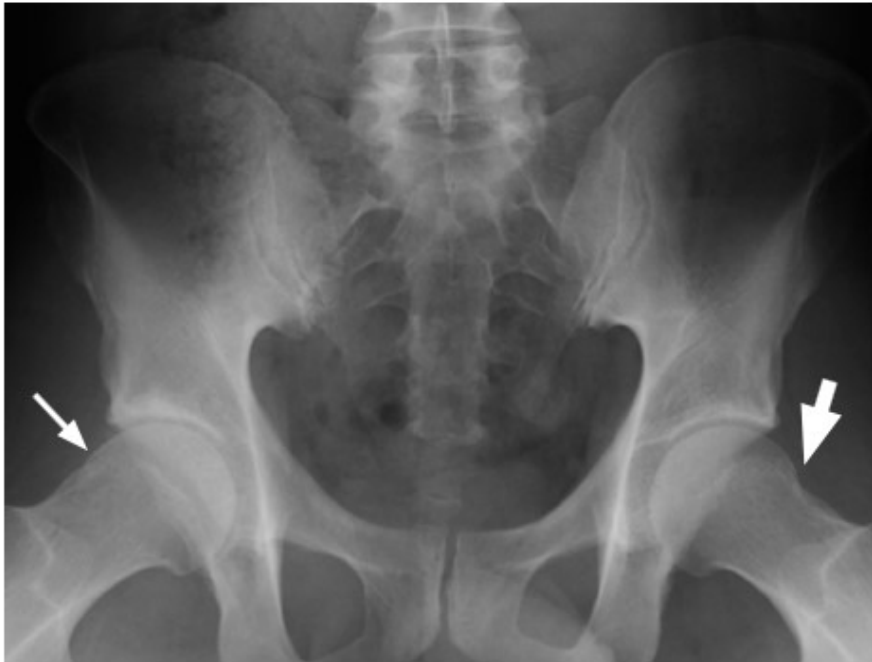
Frog leg radiograph: The thin arrow on your left indicates the area of “flattening” of the right femoral head and lack of the normal femoral head-neck offset. The thick arrow on the right indicates the more normal, rounded contour of the left femoral head.
